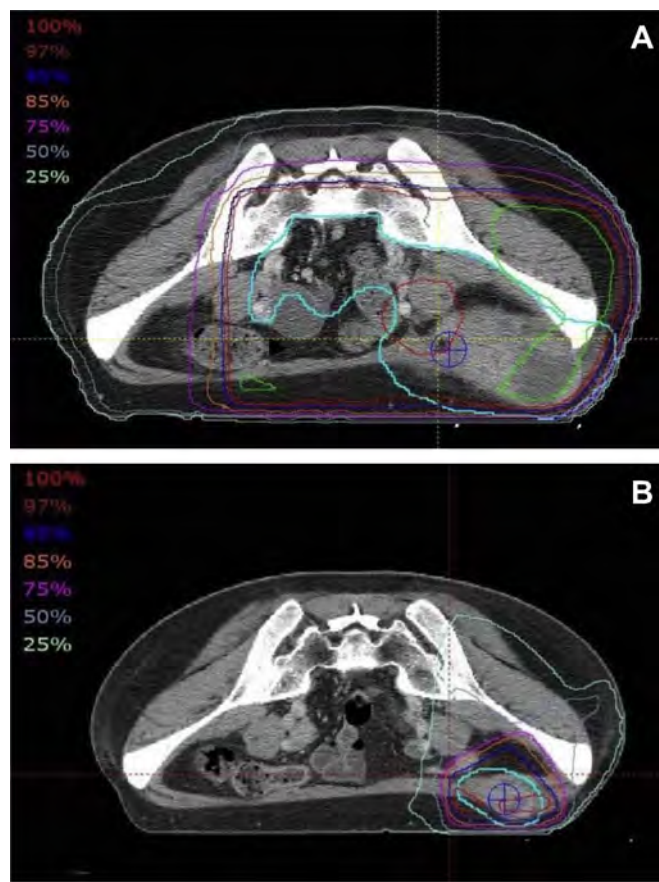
Radiotherapy. Three-dimensional conformal radiotherapy was planned to cover the clinical target volume (sky blue line) by 97% isodose lines. (A) The initial radiation field included the abdominal wall mass (port site metastasis) and pelvic disease. (B) The boost volume included the residual abdominal wall mass, and mapping was generated using new computed tomography planning.
